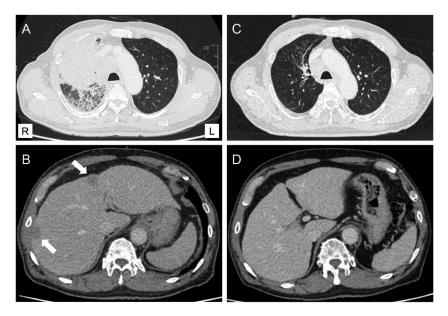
Computed tomography findings. The images at diagnosis showed a mass shadow in the right upper lobe (A) and multiple liver metastases (white arrows) (B). The images when he developed paraneoplastic cerebellar degeneration showed that the primary and metastatic tumor nodules remained in remission (C, D).
